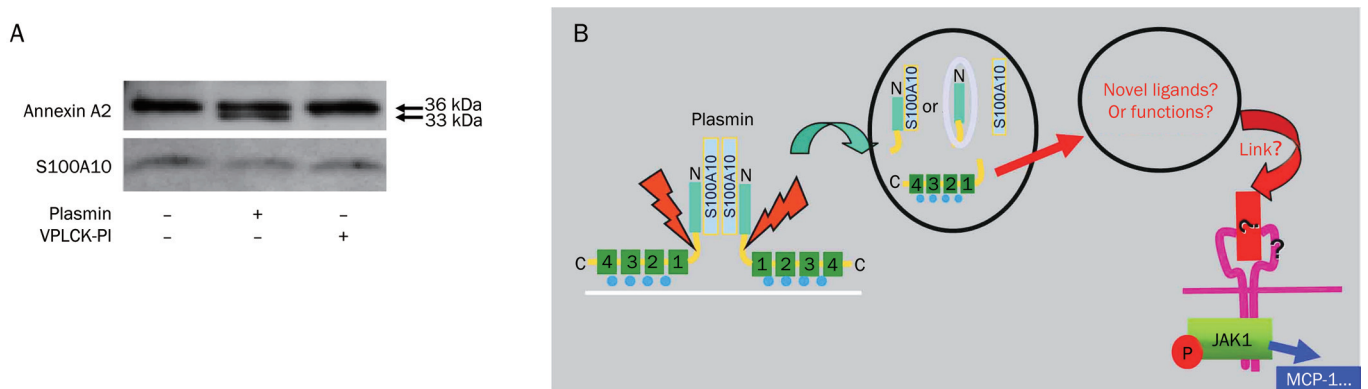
Proteolytic activity of plasmin is required for the cleavage of annexin A2 in monocytes. (A) Monocytes were stimulated for 30 min with 0.43 CTA U/mL plasmin or the equivalent amount of catalytically inactivated plasmin (VPLCK-PL). After treatment, cells were lysed, and proteins were separated and visualized by immunoblotting with antibodies against annexin A2 and S100A10. The results shown are representative of at least three independent experiments. (B) Hypothesis of the possible function of the proteolytic cleavage and dissociation of the plasmin receptor. According to consensus models, the annexin A2 heterotetramer interacts with the extracellular surface of the membrane; however, AA2t is not inserted into the membrane. After proteolytic cleavage by plasmin and dissociation of the receptor, this receptor may generate four new proteolytic fragments: either A2NPd and A2Ct, or A2Nt, A2Ct, and S100A10 alone. These fragments may interact with other proteins to form new complexes, or they may serve as novel ligands for transmembrane receptors. This result may initiate the known downstream signaling via JAKs/STATs, inducing the release of the inflammatory chemokine MCP-1.
